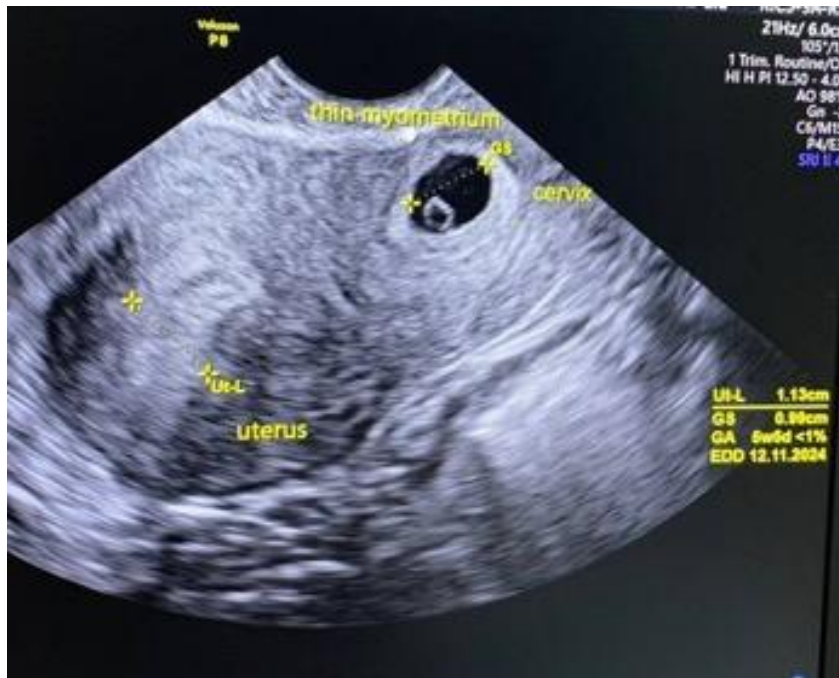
Transabdominal sonography results. The ultrasound revealed there is a gestational sac that was implanted into the thin myometrium, which was the scar of a previous pregnancy.
